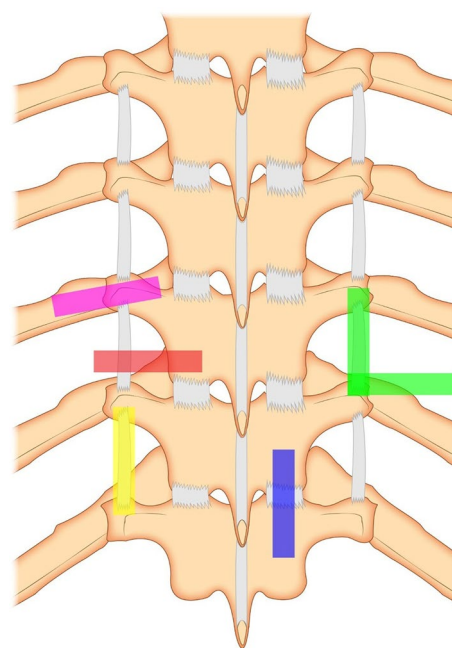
Ultrasound transducer position for each of the five thoracic interventions described. Pink—costovertebral joint injection; red—costovertebral joint injection; yellow—*erector spinae* plane block; green—medial branch block (parasagittal and axial approaches); blue—intra-articular facet joint injection
